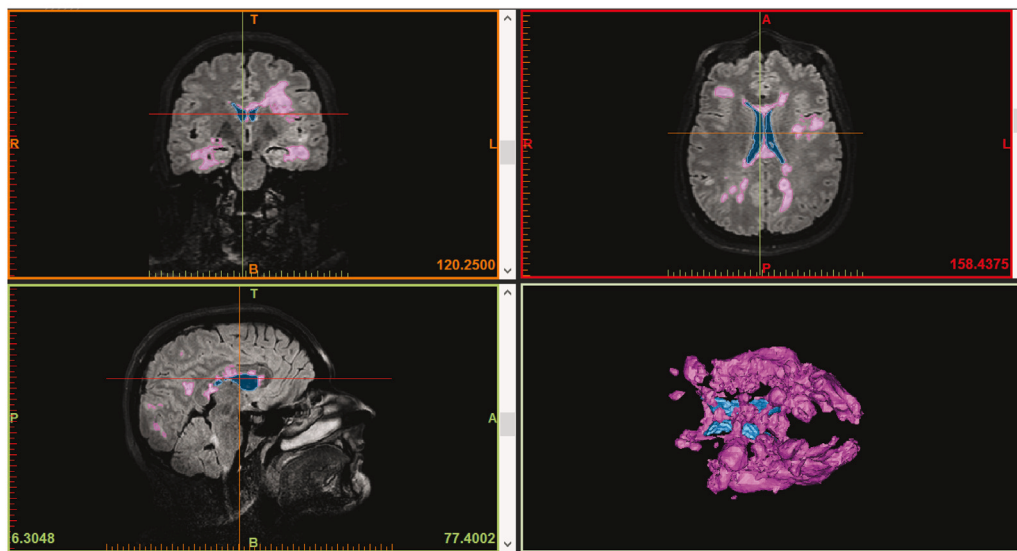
MRI images segmented into brain regions of interest in coronal, axial and sagittal planes, respectively. The pink represents the total lesion load when amalgamated from all the 3 different slices and planes.
